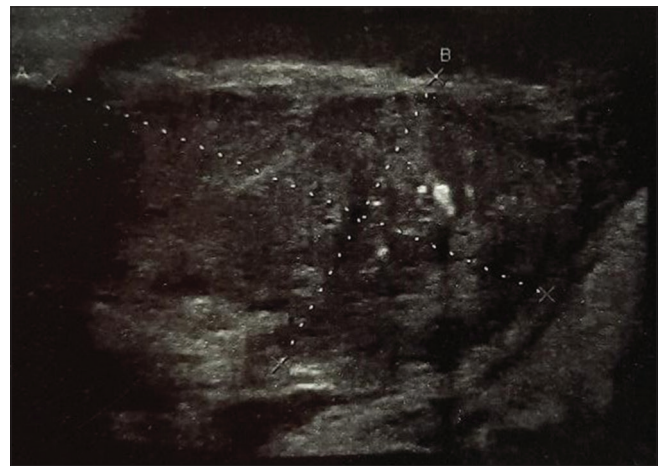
The ultrasound of the testes reported the presence of a heterogeneous mass of 12 cm × 6 cm spreading the right testicle
